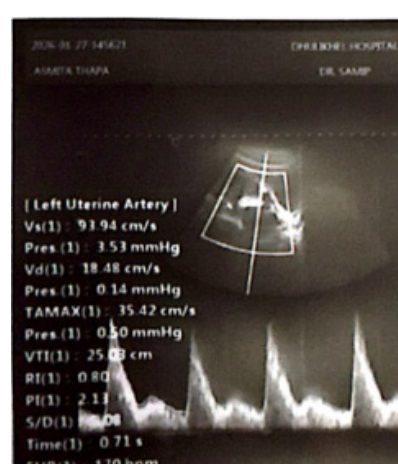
Transabdominal doppler ultrasound of left uterine artery Doppler showing raised pulsatility index 2.13 with early diastolic notching
